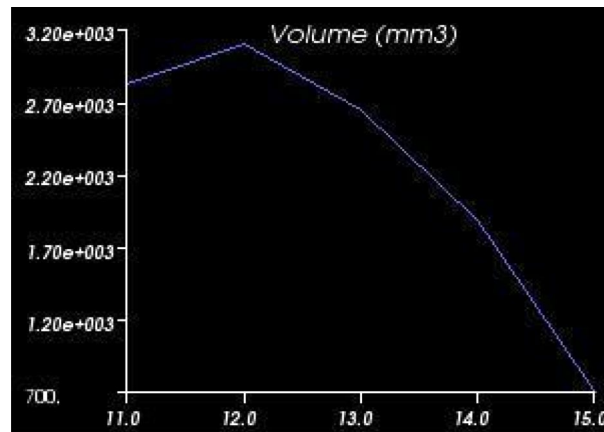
Tumor incompletely measured. Volume of each MRI slice of a tumor (y axis) against the slice number (x axis).
